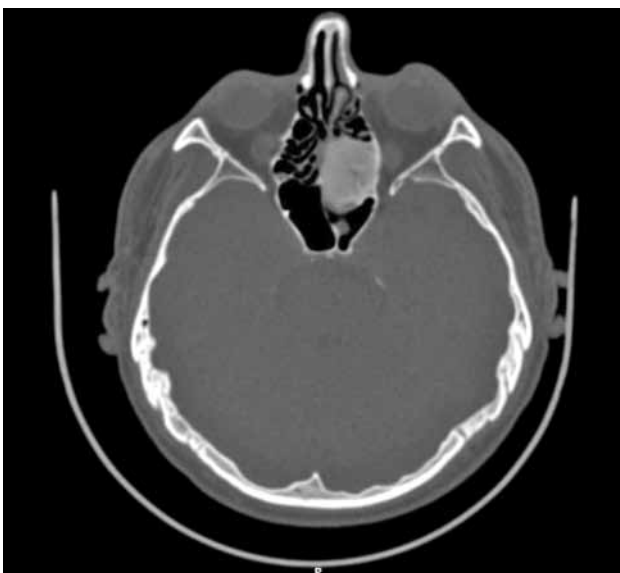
Axial computed tomography view of the osteoma in the ethmoid region.
